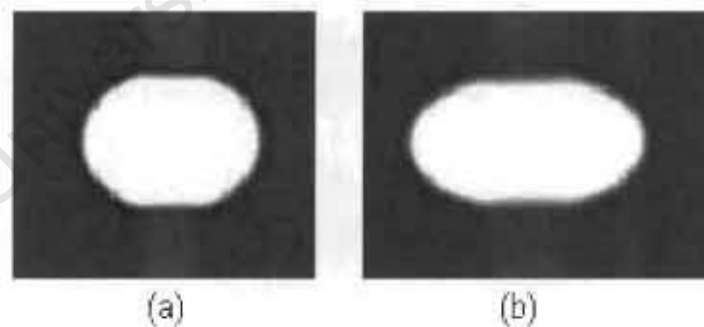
Two Statscan images showing the distortion of spherical ball bearings of the same size depending on the distance from the X-ray detectors: (a) The ball-bearing closer to the detector, (b) The ball bearing further away from the detectors. The distortion is most prominent in the image x-direction
